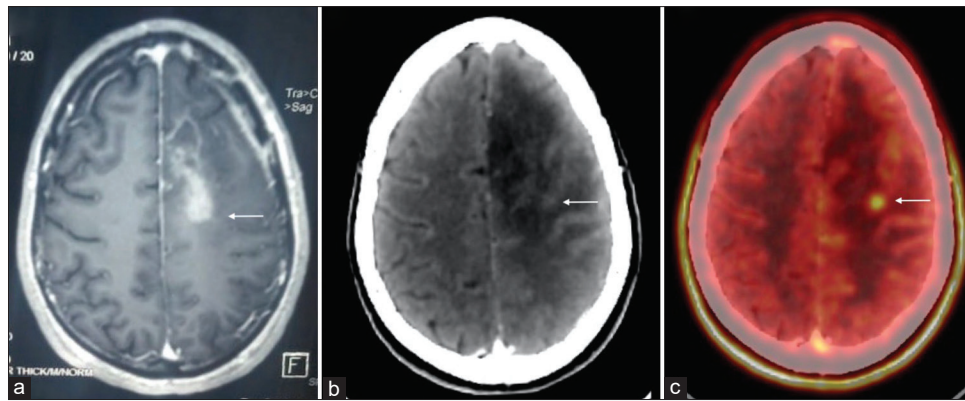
Magnetic resonance imaging axial section of the brain revealing a heterogeneous T1 postcontrast heterogeneously enhancing lesion in the left frontal lobe (a). Static images of computed tomography and fused positron emission tomography/computed tomography showing tracer-avid ill-defined enhancing subcentimetric lesion (SUVmax: 3.2) in the left prefrontal cortex (b and c)
